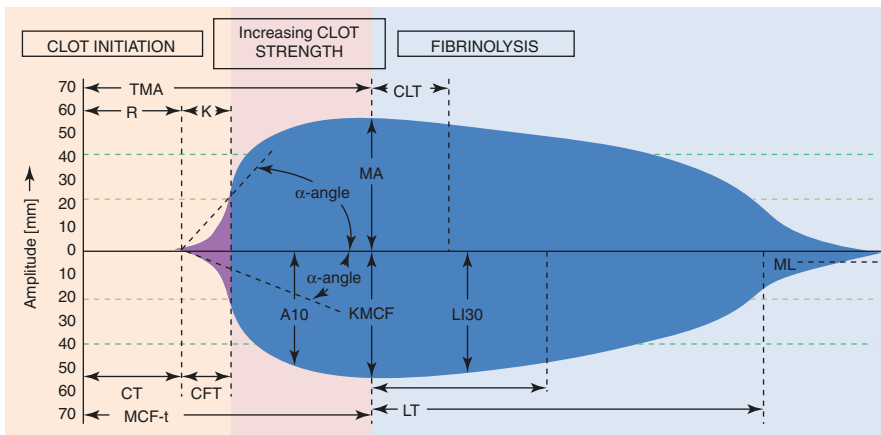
TEG and ROTEM tracing TEG parameters: *R* reaction time, *K* kinetics, α -angle, *MA* maximum amplitude, *CLT* clot lysis time (time taken for amplitude to decrease by 2 mm from *MA*). ROTEM parameters: *CT* clotting time, *CFT* clot formation time, α -angle, *A10* amplitude at 10 min, *MCF-t* time to maximum clot firmness, *MCF* maximum clot firmness, *LOT* lysis onset time, *LT* lysis time (time taken from amplitude to drop by 10% of *MCF*), *LI30* lysis Index at 30 min (% drop in amplitude from *MCF*), *ML* maximum lysis (minimum amplitude achieved at the end of test run time)
